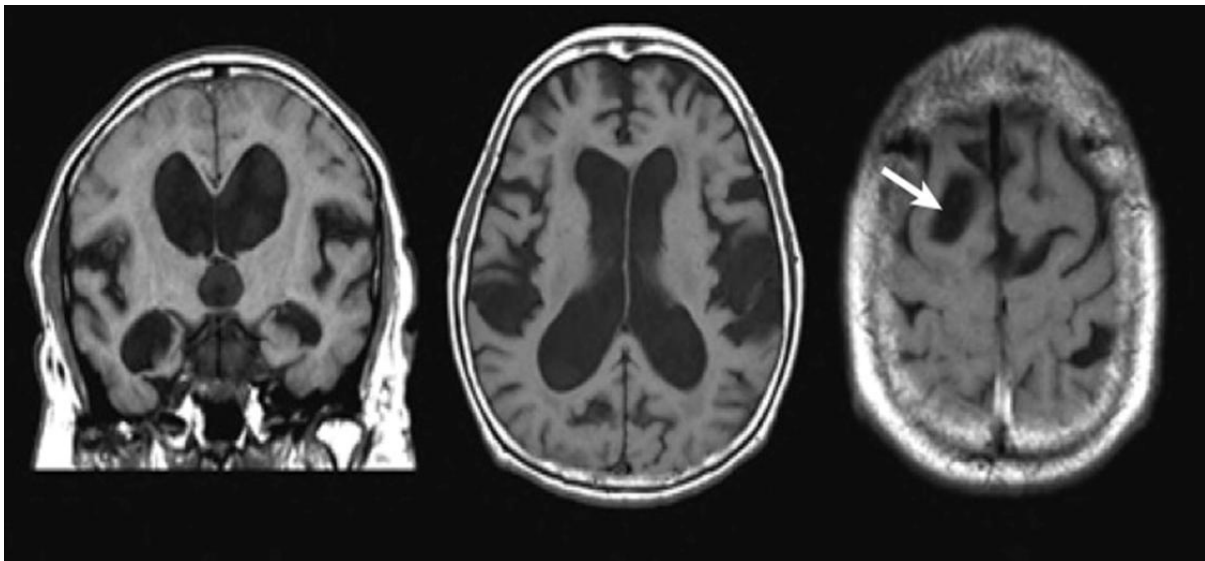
Typical MRI of a patient with iNPH [9]
